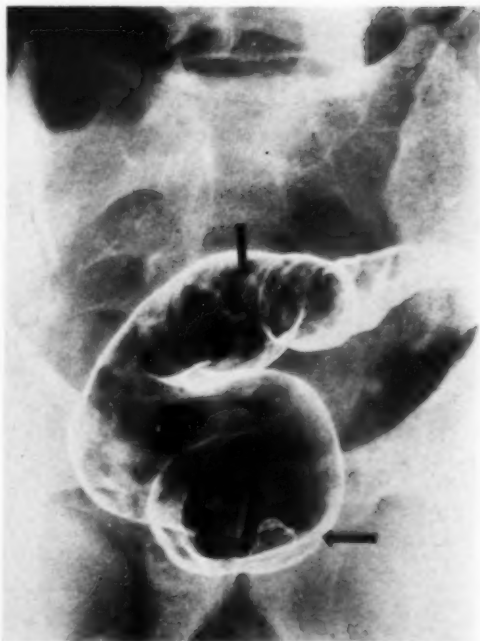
Evacuation air study of sigmoid and rectum revealing a proved polyp in the rectosigmoid and another rather low in the rectum. Digital examination of the rectum was negative and no proctoscopic examination was made before the roentgen study.
